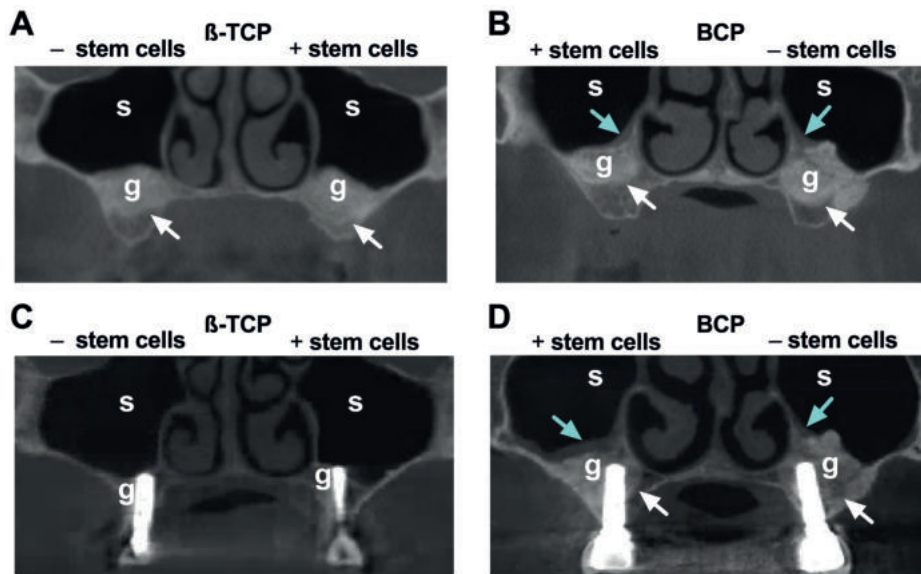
Cone beam computerized tomography (CBCT)-scans of β -TCP-treated and BCP-treated patients with and without stem cells at 5-months post-MSFE and at 10-years after implant placement. CBCT-scans of bilaterally-treated patients with: (A) β -TCP only and β -TCP plus stem cells, and (B) BCP plus stem cells and BCP only, at 5-months post-MSFE. In (A, B) homogenous radiopaque graft with a demarcation between residual native bone and the graft, and an air-filled residual maxillary sinus is visible. CBCT-scans of bilaterally-treated patients with: (C) β -TCP only and β -TCP plus stem cells, and (D) BCP plus stem cells and BCP only, at 10-years after implant placement. In (C, D) homogenous radiopaque graft, reduced graft volume, and an air-filled residual maxillary sinus is visible. g, graft; s, residual maxillary sinus; White arrows: demarcation original sinus floor; Blue arrows: Schneiderian mucosal hypertrophy.
